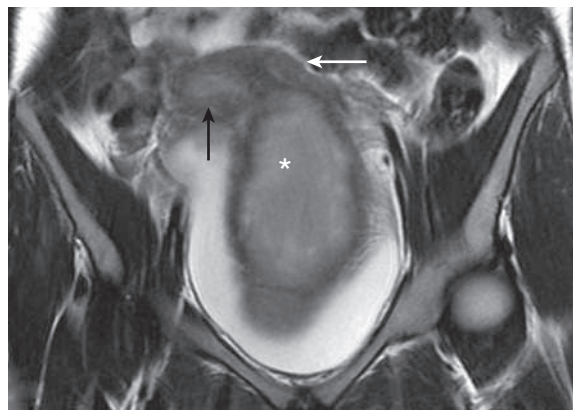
Coronal MRI demonstrating large volume hematocolpos (asterisk) in a case of uterine didelphys with longitudinal vaginal septum. Black arrow, obstructed right uterus resulting in hematometra; white arrow, unobstructed left uterus.
